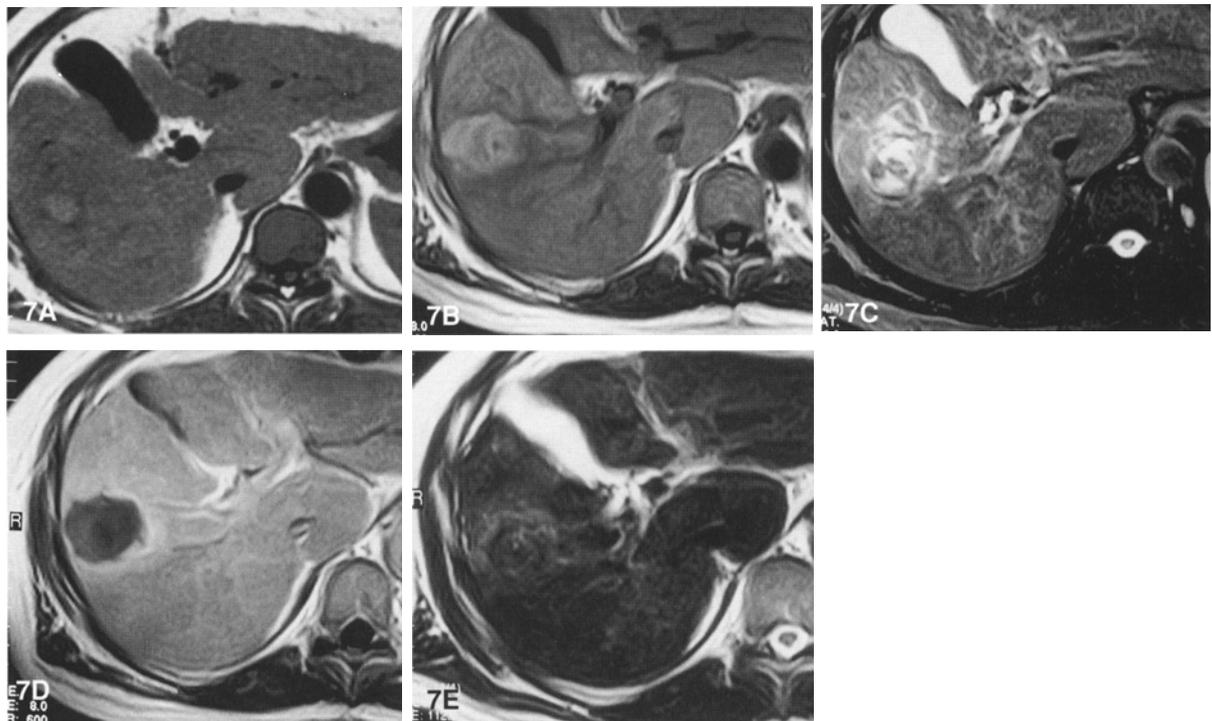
Small HCC treated with PEI and chemoembolization: MR findings. A Before treatment. On the unenhanced T1-weighted SE image a hyperintense nodule of 2 cm is seen in the right hepatic lobe, which corresponded to an HCC nodule. B Early findings after PEI. On the unenhanced T1-weighted SE image obtained after chemoembolization with doxorubicin and iodized oil and PEI, the hyperintense area has become much larger, probably due to hemorrhage. C On the corresponding T2-weighted FSE image (with fat saturation), the lesion is hyperintense. This could be due to hemorrhage or liquefactive necrosis or residual viable tumor. D On the gadolinium-DTPA-enhanced T1-weighted SE image the center of the lesion lacks enhancement, but there is intense enhancement at the periphery. These findings indicate that the center of the lesion has become necrotic but that residual viable tumor may be present at the periphery. E Follow-up 3 months after additional PEI. T2-weighted FSE image at the same level as C shows a lack of signal within the tumor. The lesion is almost isointense compared with the surrounding parenchyma. These findings indicate coagulative necrosis.
